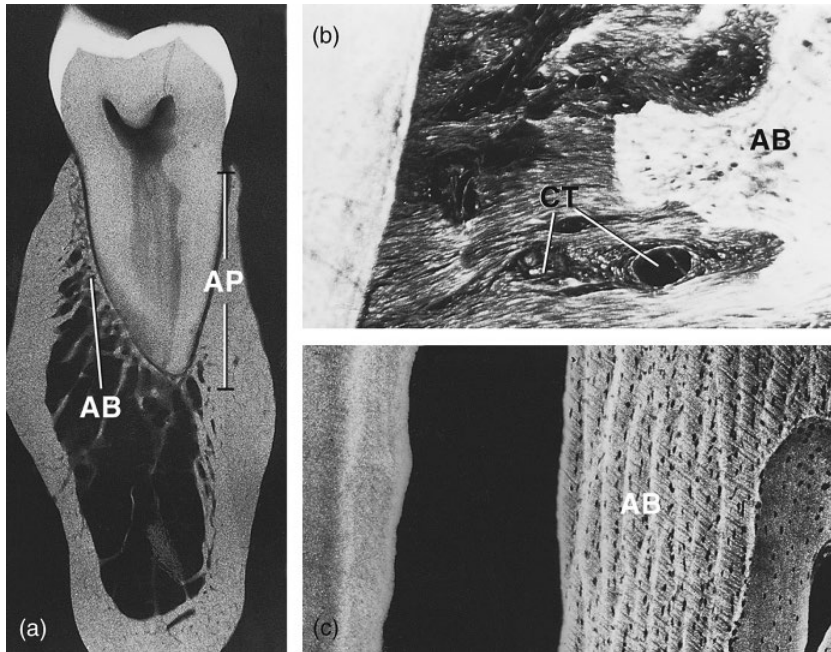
Radiograph (a) and microradiographs (b, c) of alveolar bone (AB) in undermineralized (a, c) and demineralized sections (b). Note islands of blood vessels and loose connective tissue (CT) among the fibers of the periodontal ligament and radiolucent Sharpey's fibers that attach to alveolar bone (AP, alveolar process of the mandible).
